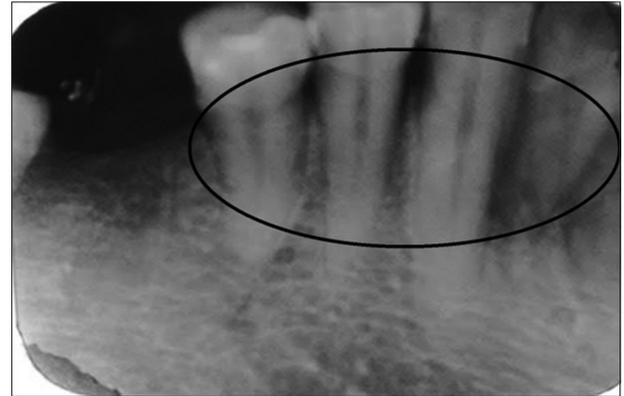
Intra oral peri-apical radiographs showing mild horizontal bone loss
